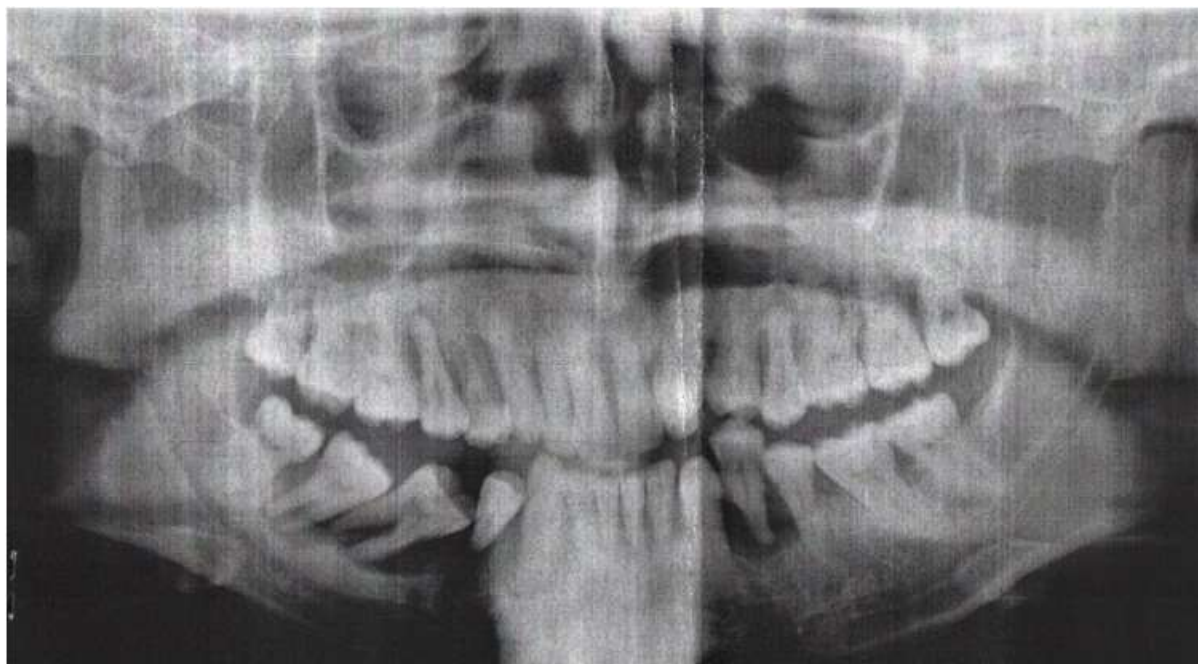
Orthopantomogram showing generalized severe bone loss
